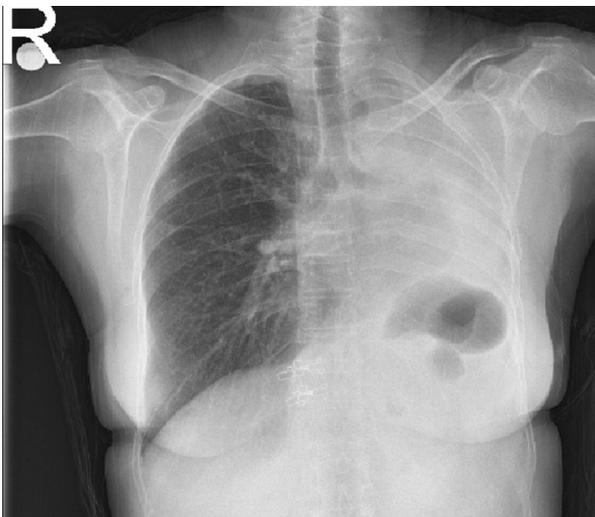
Chest radiograph of the patient with left-sided pneumonectomy.
